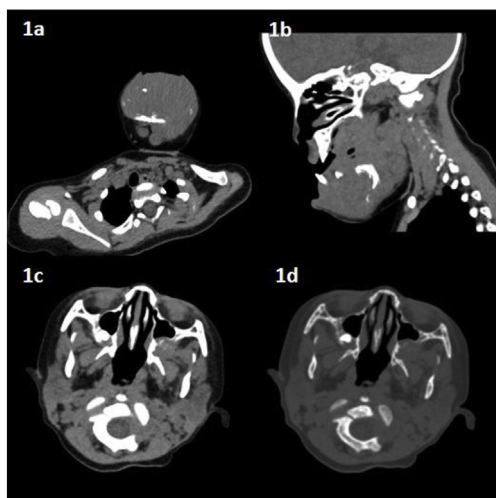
CT images at initial diagnosis. 1a and 1b Uneven-dense soft tissue masses located around maxillary and mandibular bones. 1c The mass in left maxillary sinus. 1d Destruction of superior wall of orbit bones.
